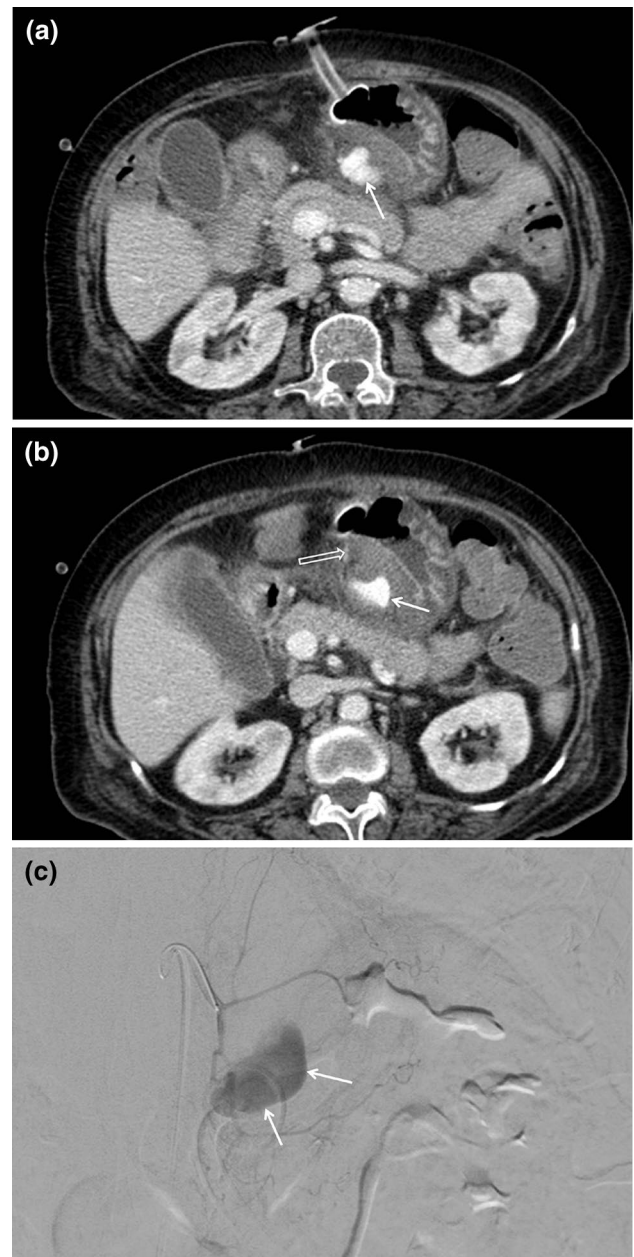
Bleeding after percutaneous endoscopic gastrostomy in a 73-year-old female with cerebral infarction. a Axial CT scan shows high-density bleeding (*arrow*) within the hematoma in the lesser sac. Note the gastrostomy tube. b Axial CT scan obtained at an *upper* level shows linear high-density contrast extravasation (*open arrow*) from the gastrostomy tube. Note the irregular-shaped high-density bleeding (*arrow*). c Subsequent angiography reveals a pseudoaneurysm (*arrows*) from the branch of the left gastric artery
